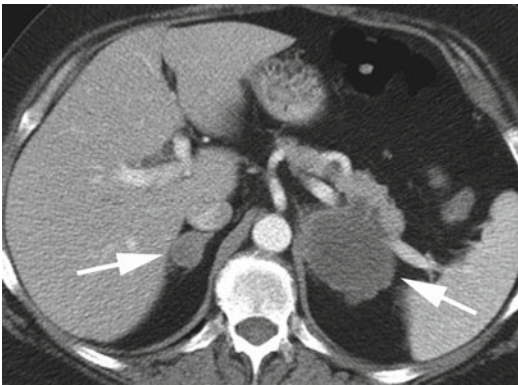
Adrenal metastases. Axial CT image reveals necrotic low attenuation adrenal metastases (*arrows*)
